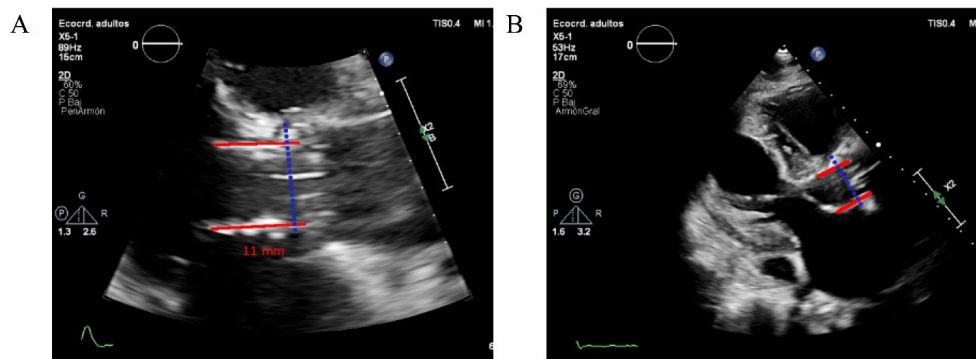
2D transthoracic echocardiography images in the aortic longitudinal plane showing the measurement of the valve implantation depth. A) Patient with a low valve implant ratio (30:70). B) Approach with measurements for a patient with a very low implant ratio (10:90) and the need for postoperative permanent pacemaker implantation (11 mm from the annulus line [dashed line]).
